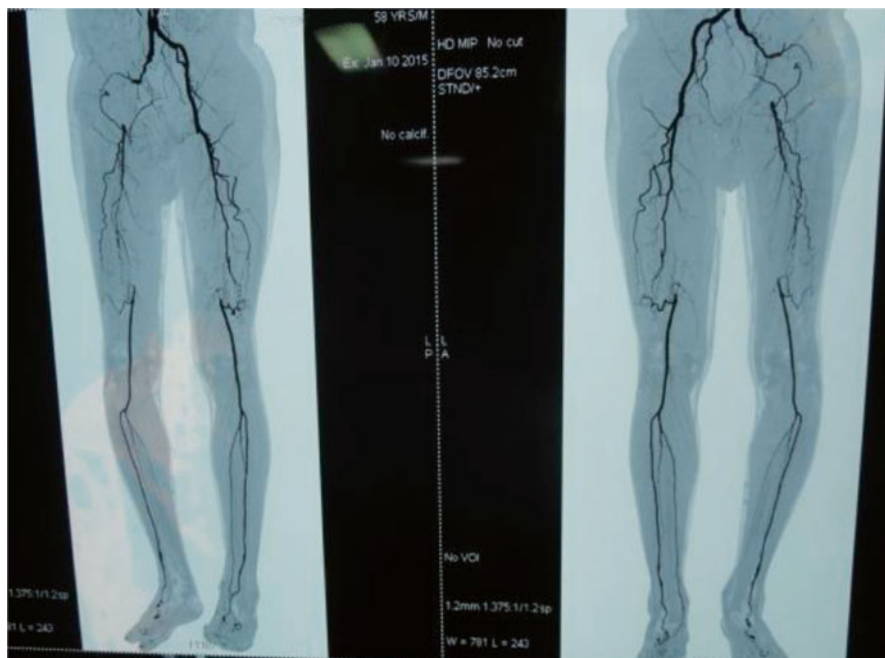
CT angio showing bilateral femoral block at variable levels
